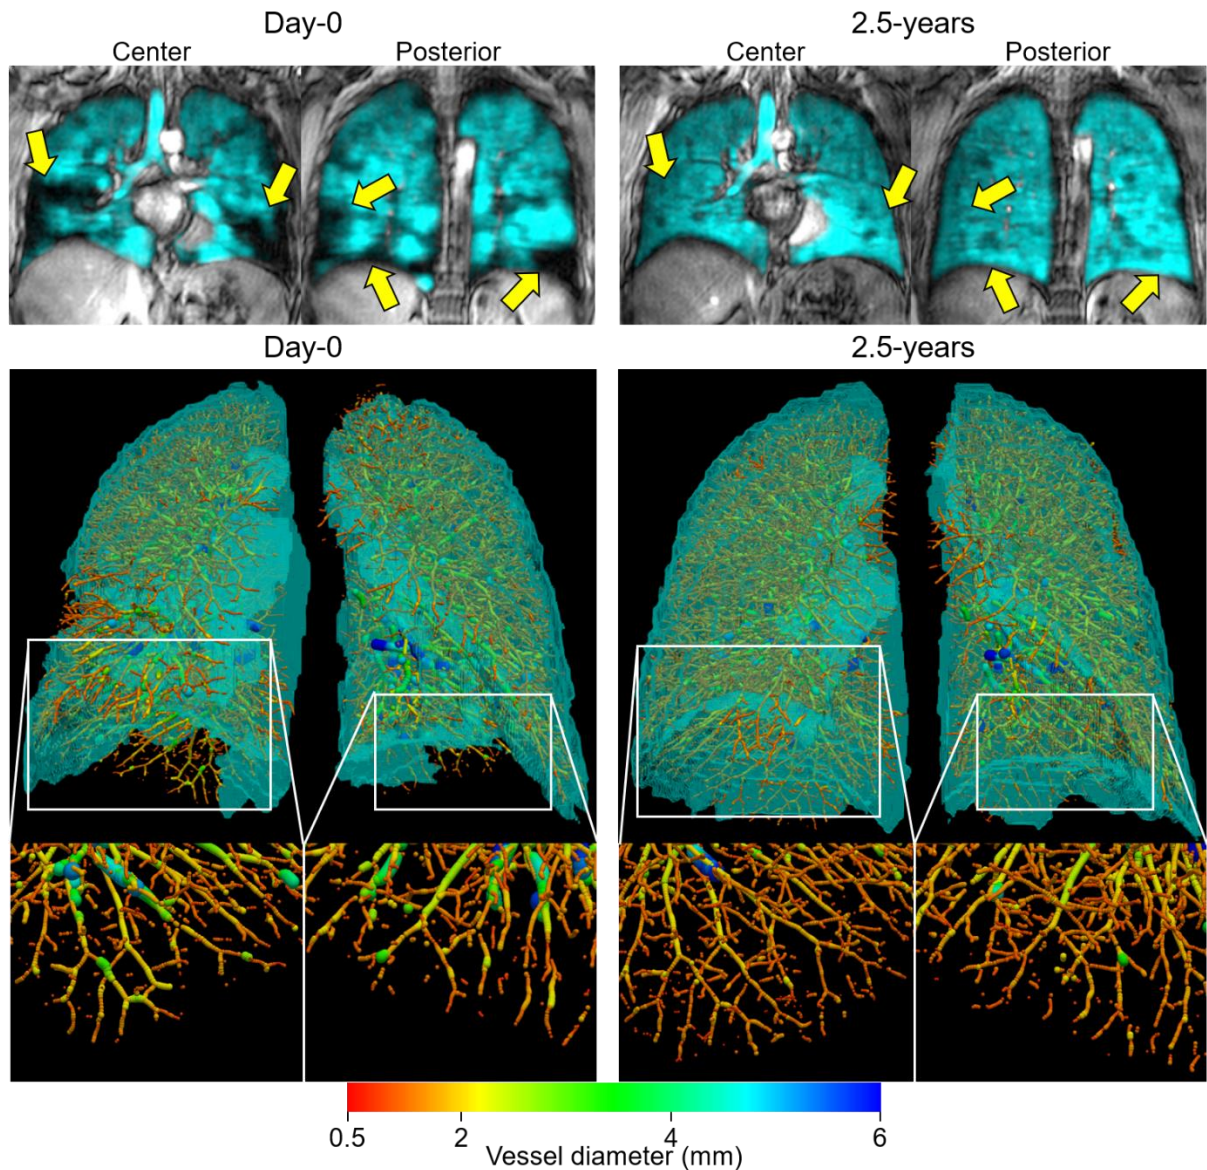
Vascular and MRI ventilation improvement at 2.5-years
